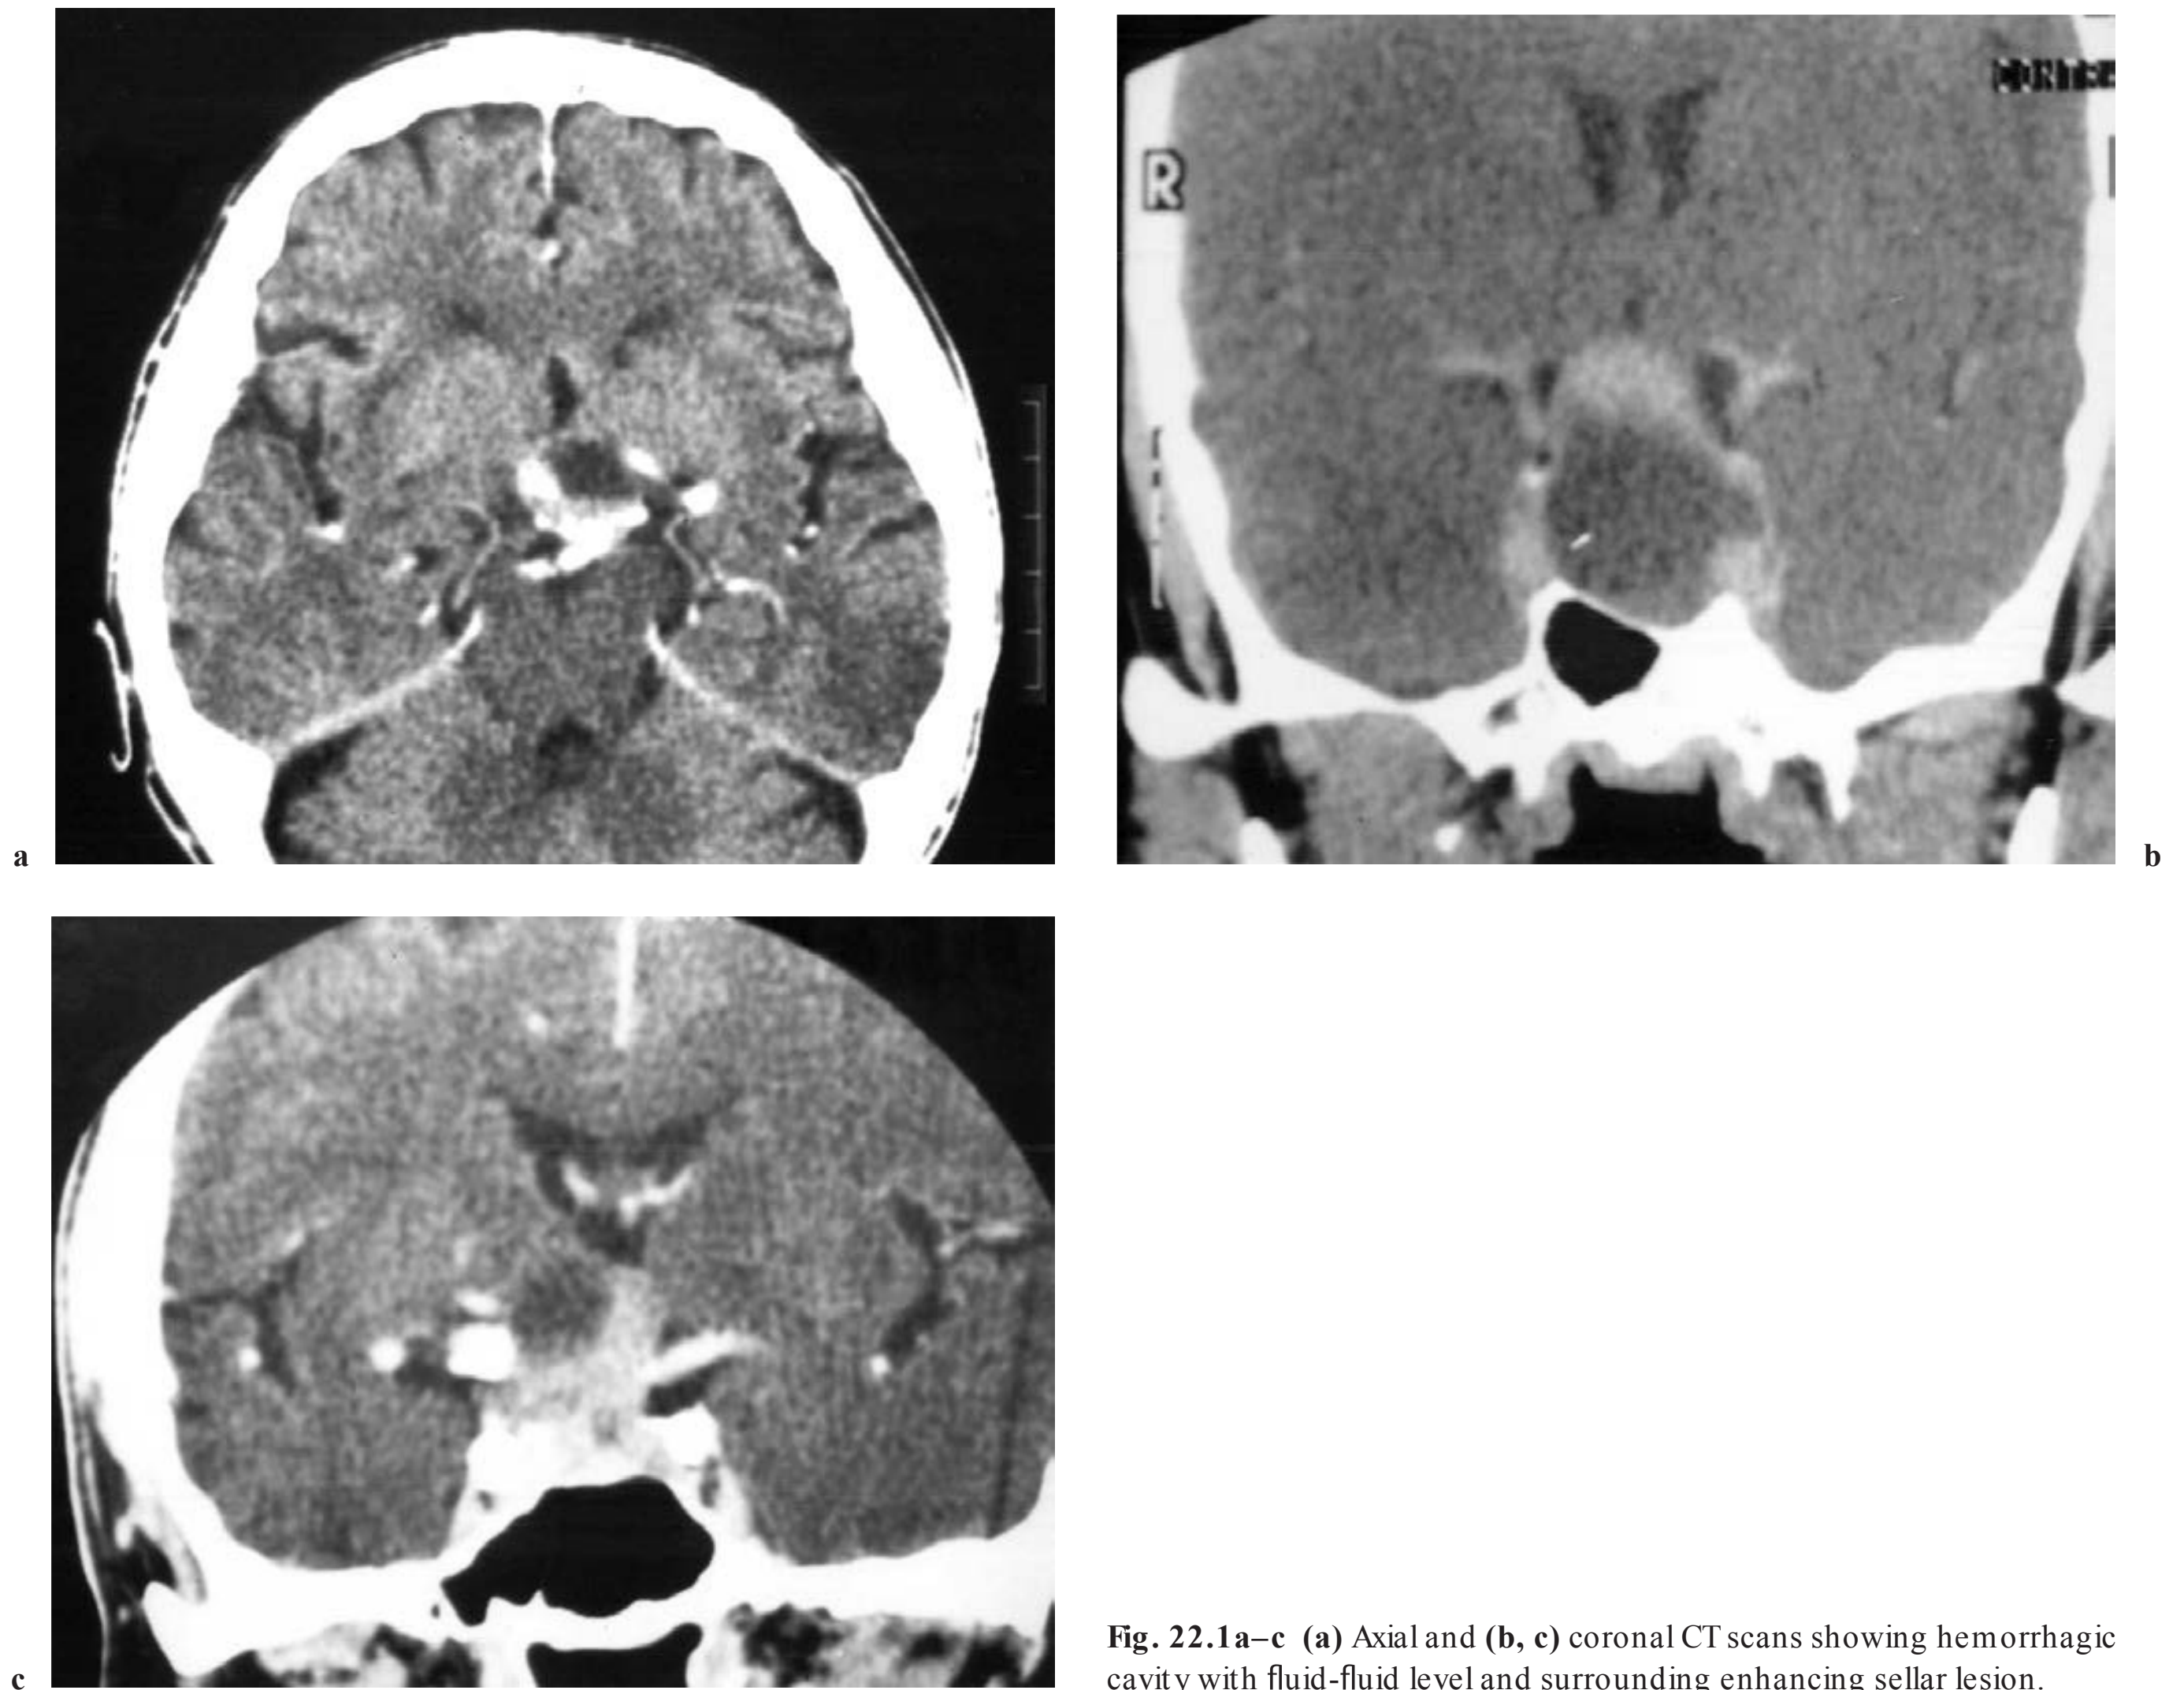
c (a) Axial and (b, c) coronal CT scans showing hemorrhagic cavity with fluid-fluid level and surrounding enhancing sellar lesion.
